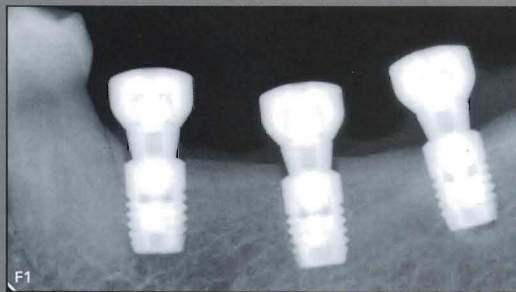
Short implants can be particularly beneficial when used in posterior regions where access can be difficult. FIG 2: Postoperative view demonstrates successful placement of a short (< 10 mm) implants. FIG 3: One-year radiograph of a 4.0s x 6-mm OsseoSpeed™ implant (Astra Tech) placed to replace a missing maxillary first molar with limited vertical height due to sinus proximity. FIG 4: Marginal bone loss in mesial and distal aspects of short- and standard-length OsseoSpeed implants (Astra Tech).
